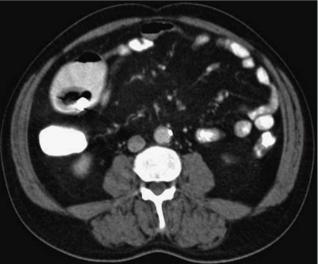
Computed tomography (CT) image demonstrating a dilated part of the bowel, filled with the enteral contrast (given orally), and containing the capsule and multiple enteroliths, each with a thick rim of intermediate density and low-density center.
